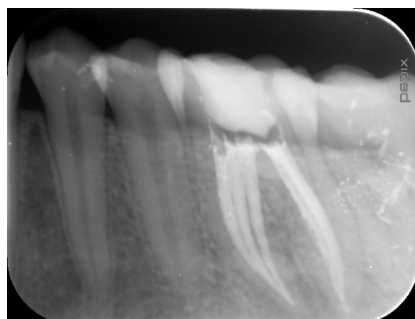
Postoperative radiograph of tooth 46 in oblique distal projection showing that all mesial canals have separated orifices and join in the apical third of the root. Both canals of the distal root are also visualized.
